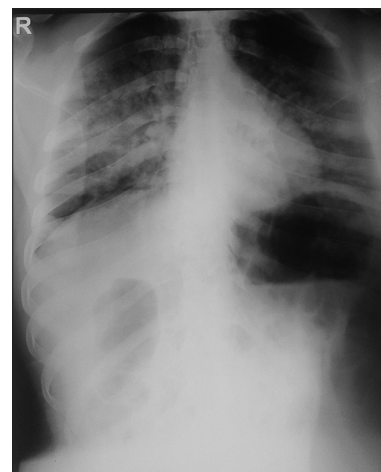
Bedside supine X-ray chest anterior-posterior view shows multiple inhomogeneous airspace opacities in the right lung mid zone and both side lower zones - likely aspiration pneumonitis. Cardiac silhouette, pleural spaces, and soft tissues are normal
